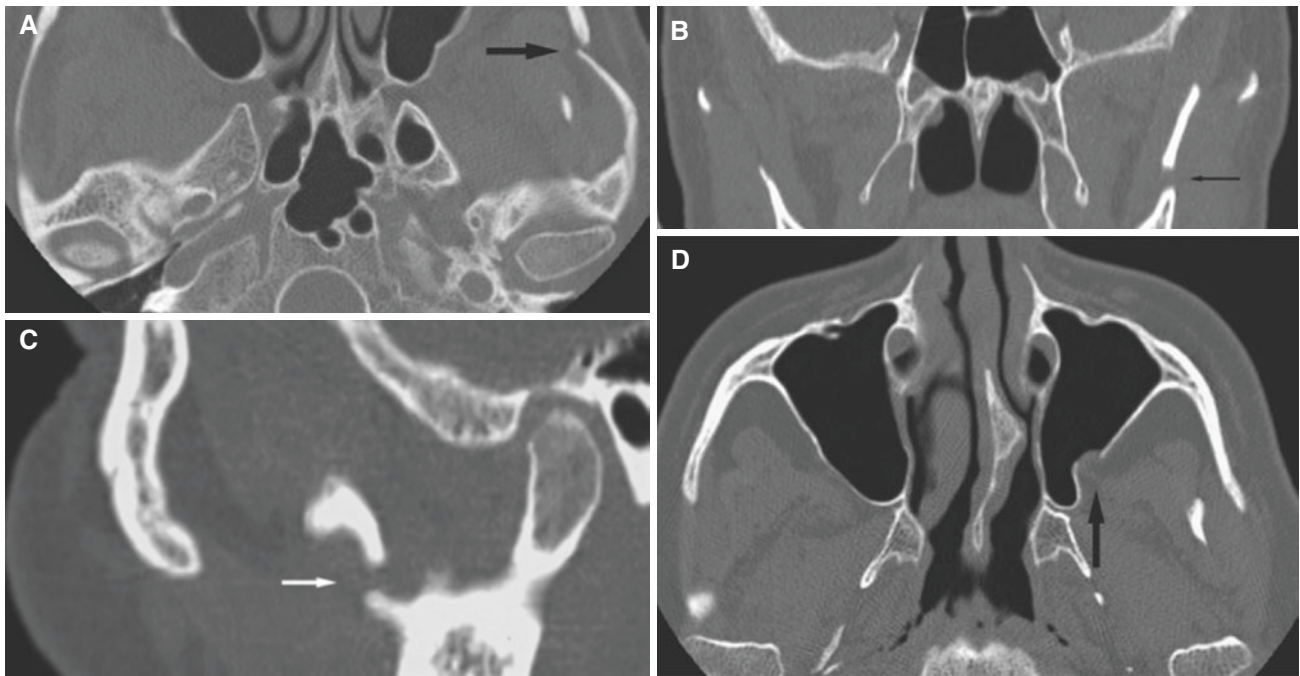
Mandibular coronoid process, maxillary sinus wall and zygomatic arch fractures; 54-year-old female with bicycle accident 3 weeks previously, but still with mouth-opening problem. (A) Axial CT image shows fracture of zygomatic arch (*arrow*). (B) Coronal CT
